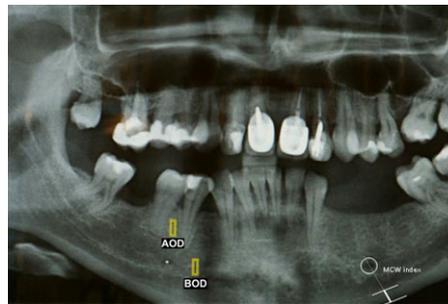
Digital panoramic radiograph with the three measurement variables: AOD: alveolar optical density; BOD: basal optical density; MCW index. Asterisk: mental foramen.
